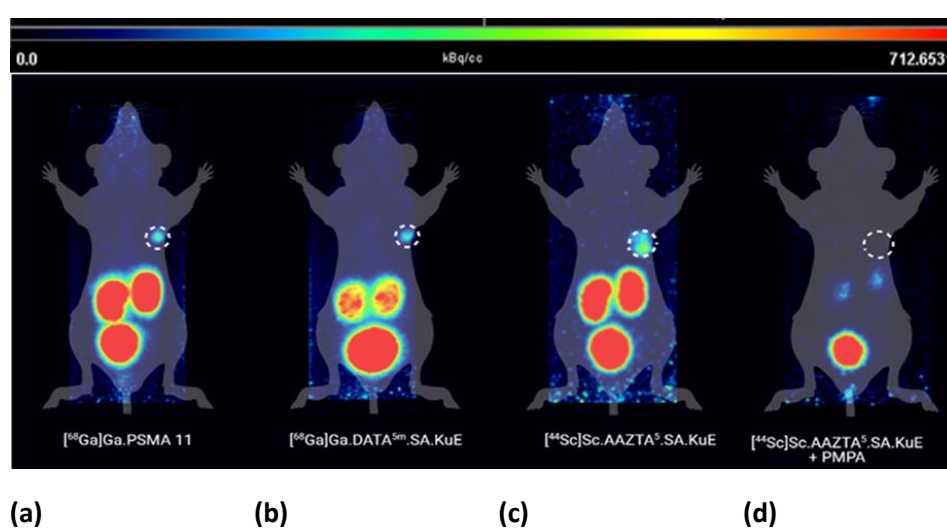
Maximum intensity projections of μ PET scans 1 h p.i. of (a) $[^{68}\text{Ga}]\text{Ga-PSMA-11}$, (b) $[^{68}\text{Ga}]\text{Ga-DATA}^{5\text{m}}.\text{SA.KuE}$, (c) $[^{44}\text{Sc}]\text{Sc-AAZTA}^{5\text{m}}.\text{SA.KuE}$ and (d) co-injection of $[^{44}\text{Sc}]\text{Sc-AAZTA}^{5\text{m}}.\text{SA.KuE}$ and PMPA (tumor circled).
